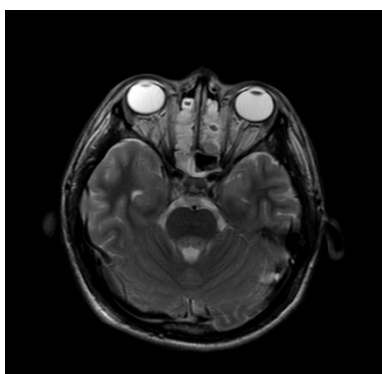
Axial T2 MRI series show hyperintensity in dorsal pons
